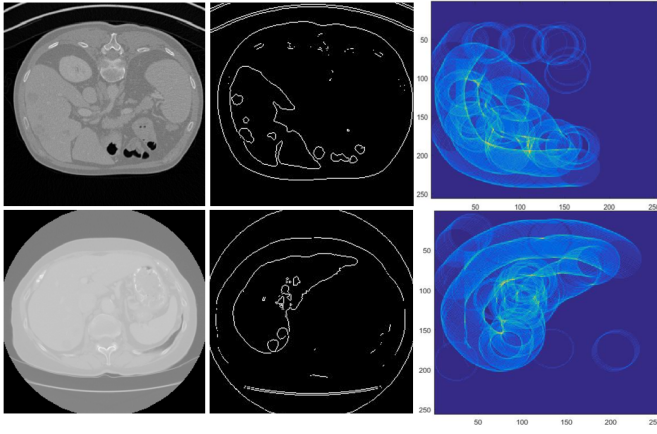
The first column shows slice of CT images from LiTS dataset and second column shows the binary detected edge and last column is Hough transform accumulator for detection of curved shape.
